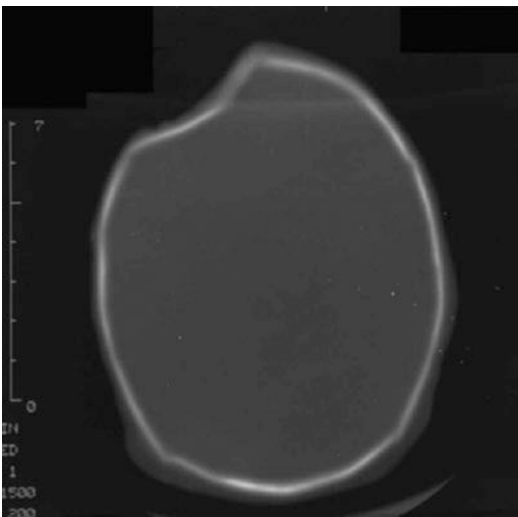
CT of the infant with depressed skull fracture
